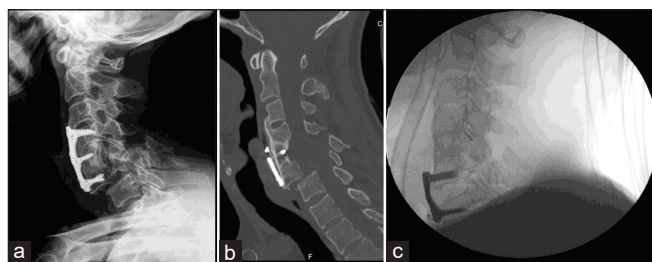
(a) Admission X-ray after second paragliding accident, March 2014: lateral view C6-C7 dislocation. (b) Admission computed tomography scan after second paragliding accident, March 2014: lateral view C6-C7 dislocation. (c) Fluoroscopic intraoperative lateral view: C6-C7 anterior cervical discectomy and fusion with iliac crest autograft (Smith-Robinson) and C6-C7 plate.
